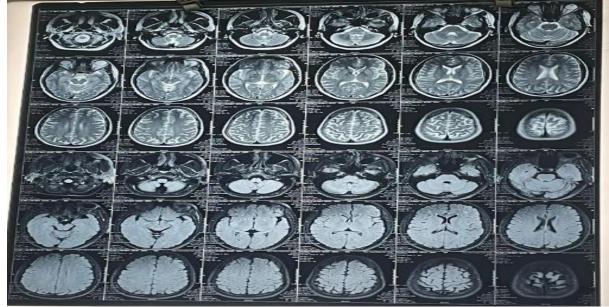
MRI scan had been suggestive of "Partially Empty Sella"
